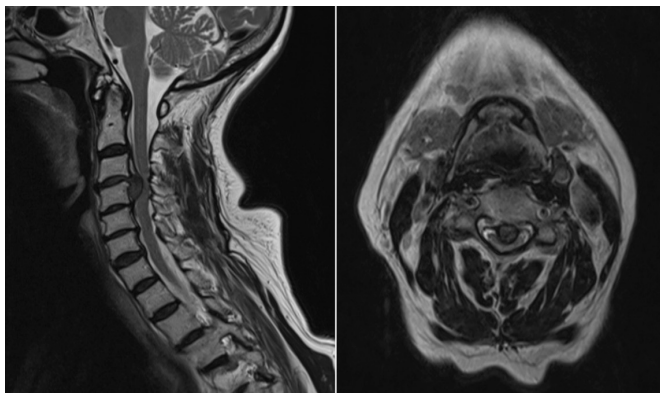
MRI T2WI sagittal (left) and axial (right) views demonstrating a large disc prolapse at C3/4 with inferior migration behind the vertebral body of C4 causing severe spinal cord compression. T2WI, T2-weighted image.
